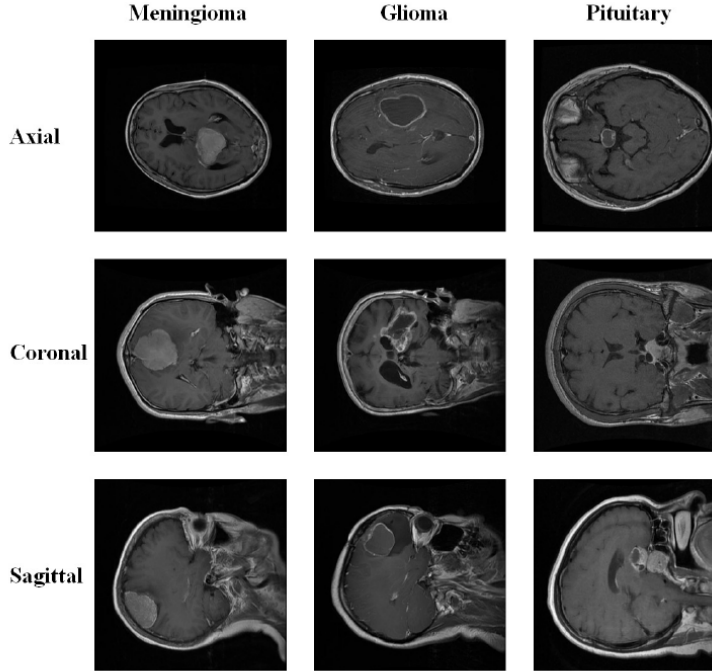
Samples of CE-MRI images
